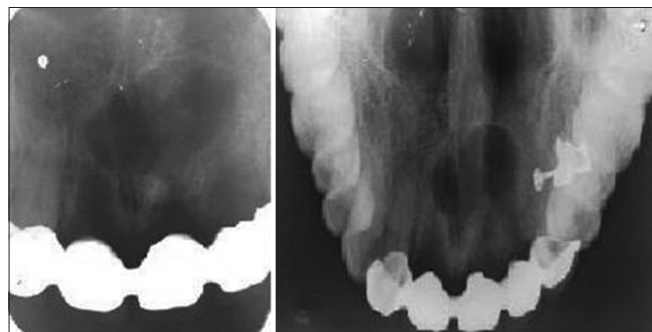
Intraoral radiographs revealed missing 11, 21, and 22 and ovoid radiolucency at the periapical region of 21 and 22 (arrow) measuring approximately 2.5×1.5 cm surrounded by a corticated border
